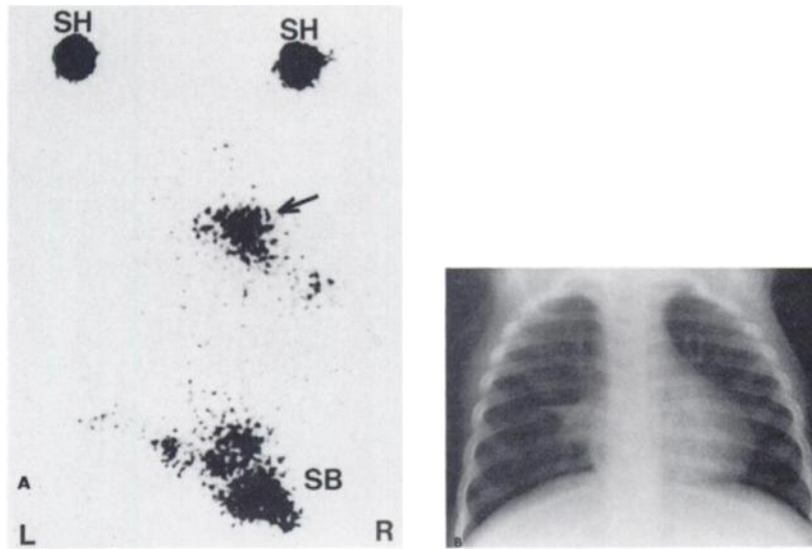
(A) Posterior image of thorax obtained 4 hr after oral ingestion of Tc-99m sulfur colloid in 4-mo-old girl (Patient 3, Table 1) shows abnormal site of activity in right mid-lung field. SH = shoulder markers, SB = small-bowel activity. Activity corresponds to region of infiltration seen in radiograph (B).
